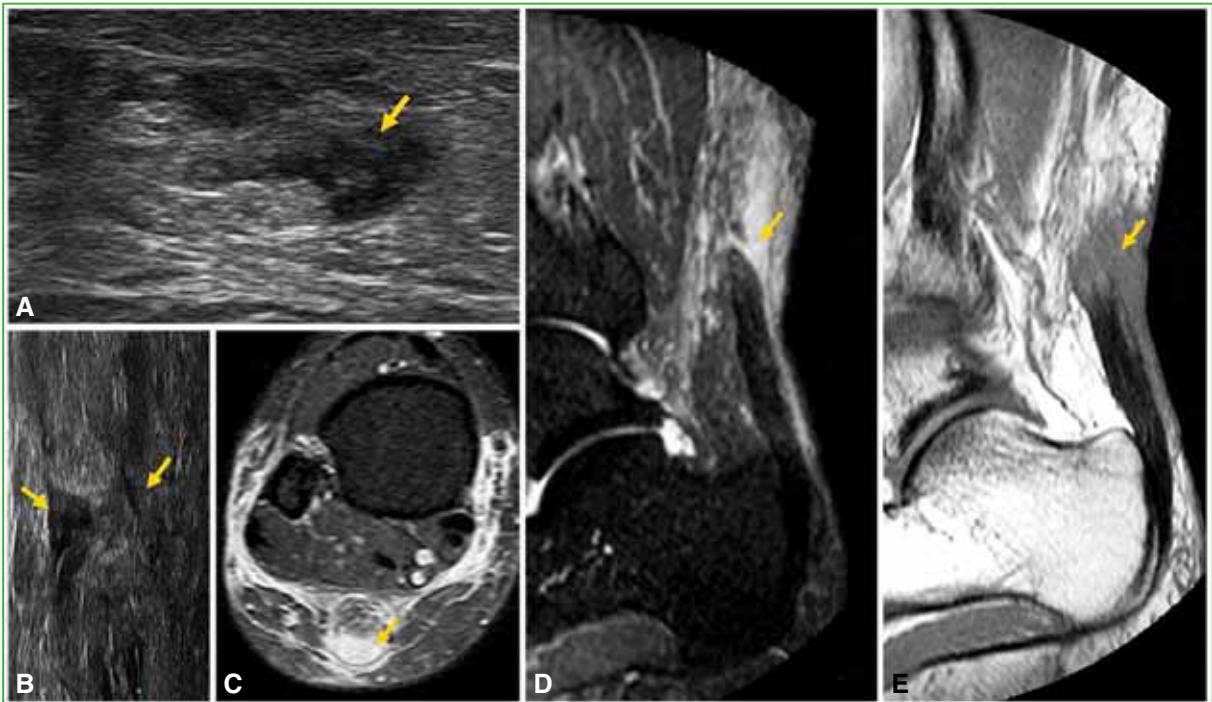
Short (A) and long (B) axis ultrasound, axial STIR (C), sagittal STIR (D), and T1 (E) sequences showing a complete tear of the Achilles tendon in the proximal third.
